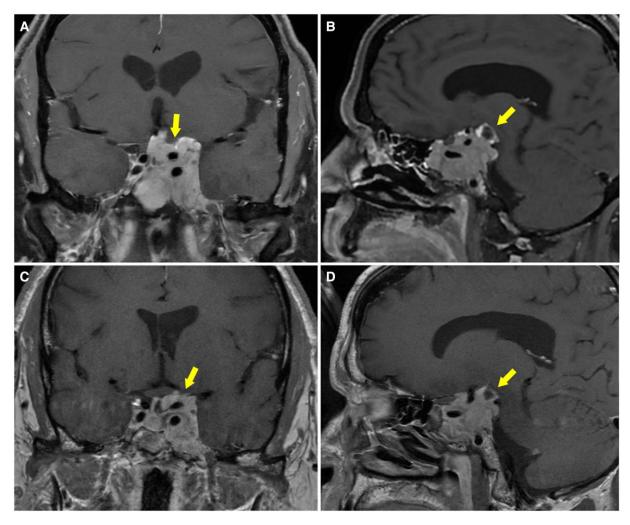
Gadolinium-enhanced T1-weighted MRI of the sella. (A) In the coronal view, a large sellar mass measuring up to 4.2 cm was observed invading the left cavernous sinus and encasing the left internal carotid artery (arrow), with superior displacement of the optic chiasm. (B) In the sagittal view, tumoral cyst was visualized within the suprasellar cistern (arrow). (C, D) Following subtotal transsphenoidal resection, the tumor measured up to 2.6 cm with similar encasement of the left internal carotid artery (coronal, arrow) and decrease in size of the tumoral cyst (sagittal, arrow).
